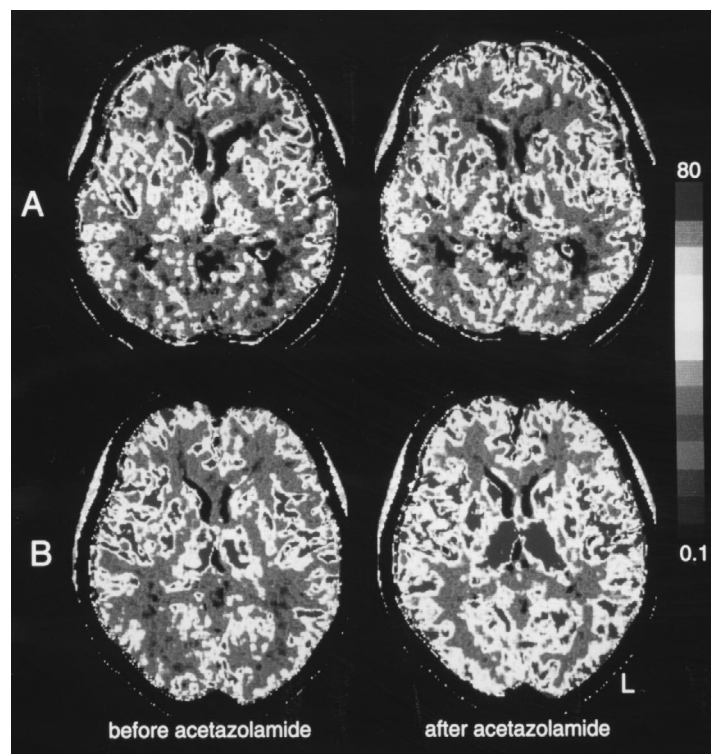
Xenon computed tomography before and after intravenous injection of acetazolamide. (A) Asymptomatic cerebral thrombosis and (B) control.
